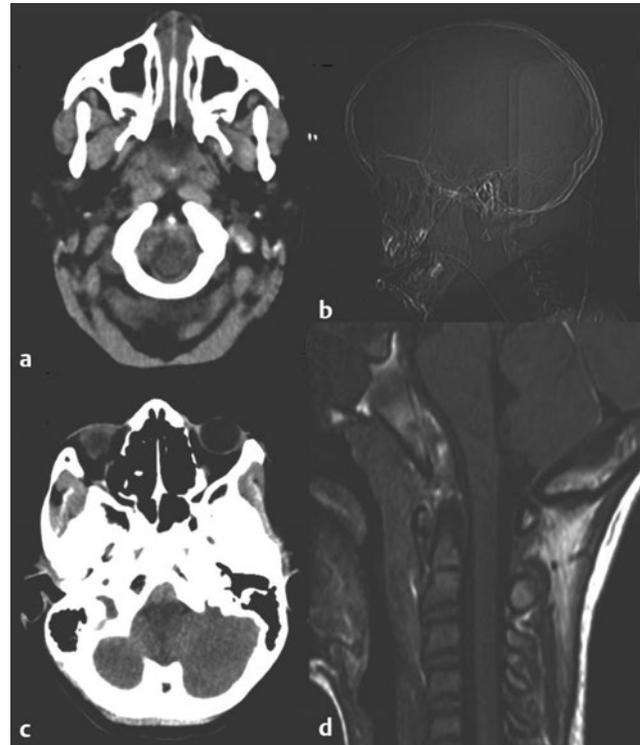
Retroclival hematomas. (a) Axial computed tomographic (CT) scan of the head showing a collection of blood ventral to the lower brainstem. (b) Atlantoaxial disruption in the same patient. (c) CT scan of the head of a different patient showing a more subtle image of blood ventral to the brainstem. (d) Magnetic resonance image of the same patient showing the retroclival hematoma ventral to the brainstem.
